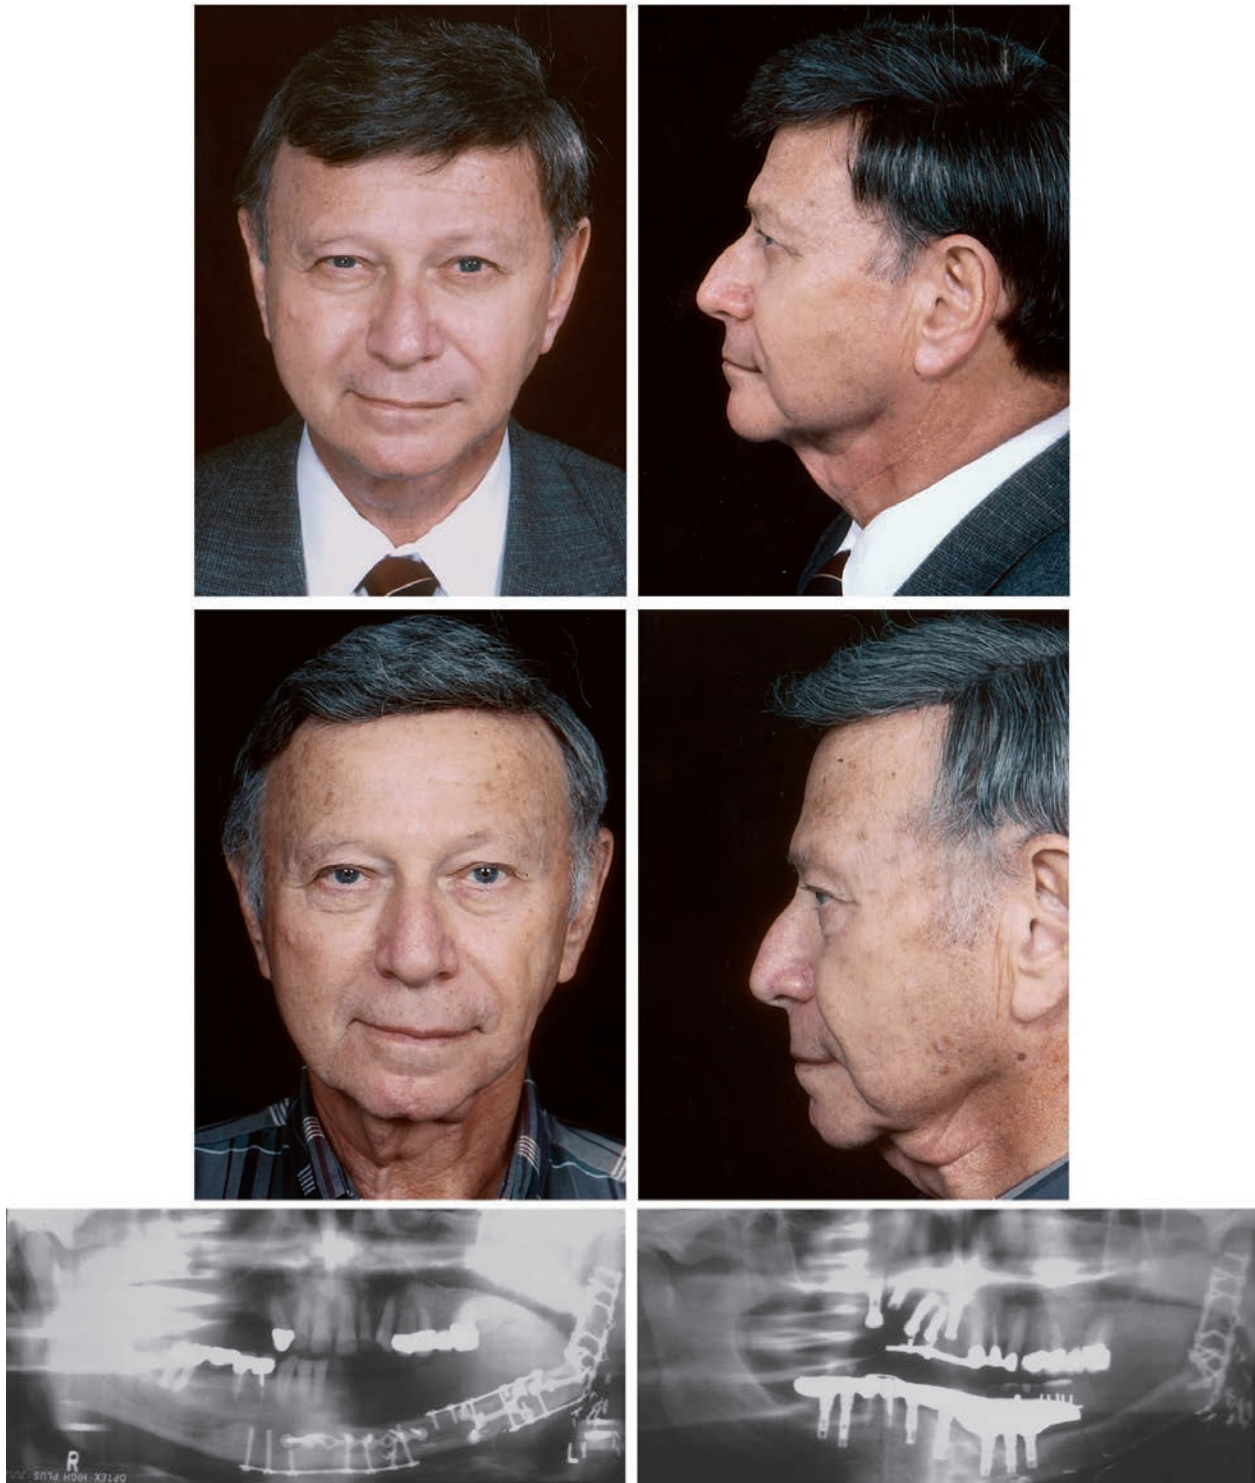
Patient 5 in Tables I and II. (*Above*) Postoperative views at 1 year 6 months. (*Center*) Postoperative views at 12 years 7 months. Facial asymmetry has become more obvious with aging (*Below, left*) Early postoperative Panorex radiograph. (*Below, right*) Panorex radiograph at long-term follow-up shows extensive dental reconstruction with osseointegrated implants.
